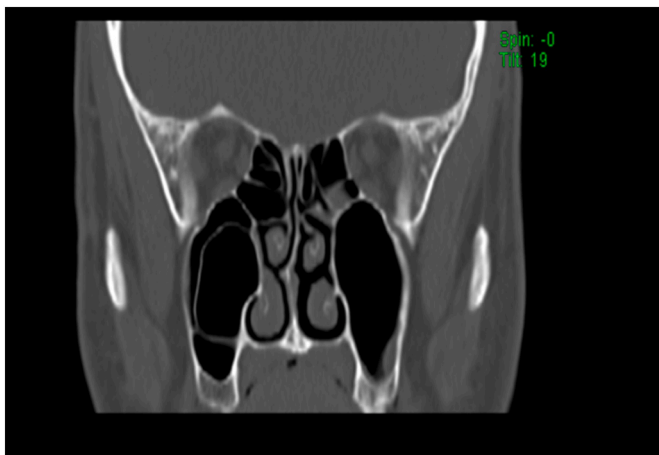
Coronal section of CT air cell in the right maxillary sinus with evidence of hypertrophied inferior turbinate.
